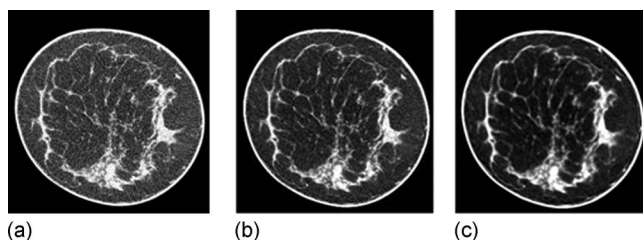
(A) The original reconstructed CT data. (B) The data with ten denoising iterations, as optimal for image review. (C) The data with 40 denoising iterations to perform maximum noise reduction for segmentation purposes only.
